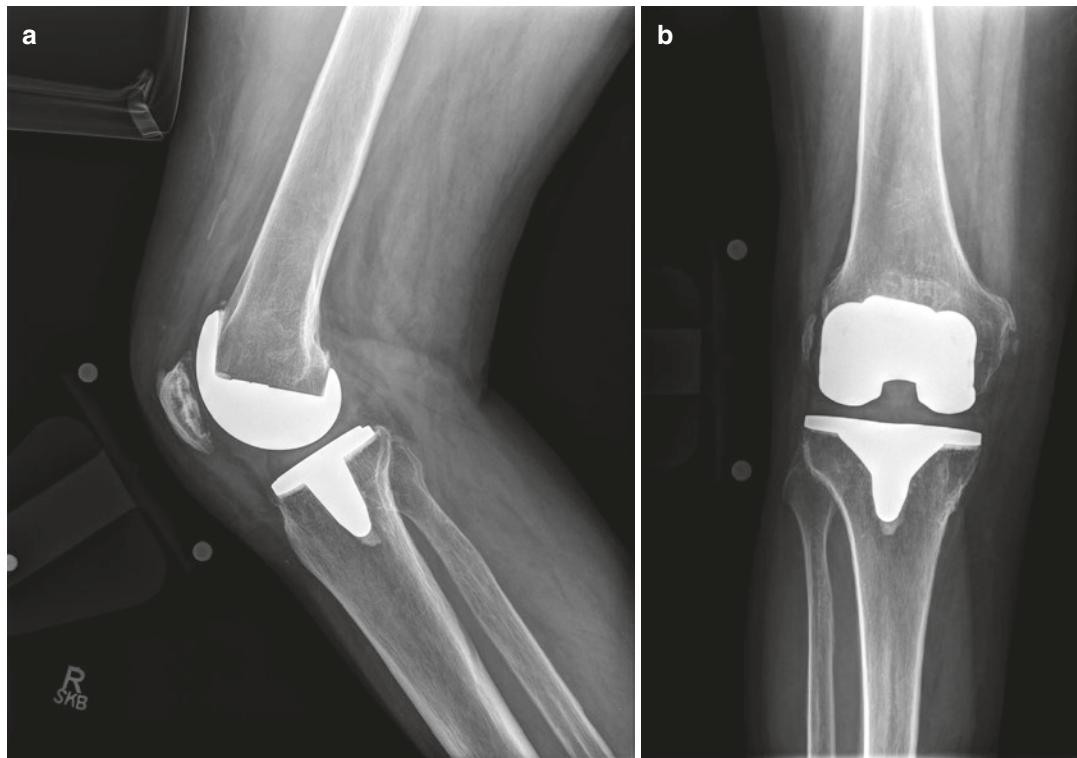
Presenting anteroposterior (AP) (a) and lateral (b) radiographs
